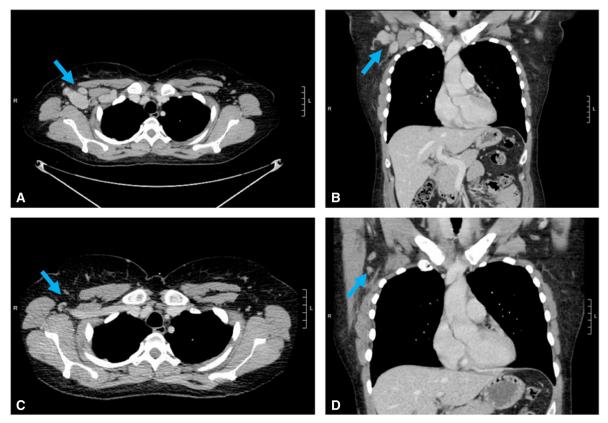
Preoperative (A) axial and (B) coronal CT images showing lymph nodes characteristic of axillary Castleman disease. Postoperative (C) axial and (D) coronal CT images demonstrate the success of the procedure. The presence of few residual lymph nodes is noted, with the largest measuring 1.3 cm.
